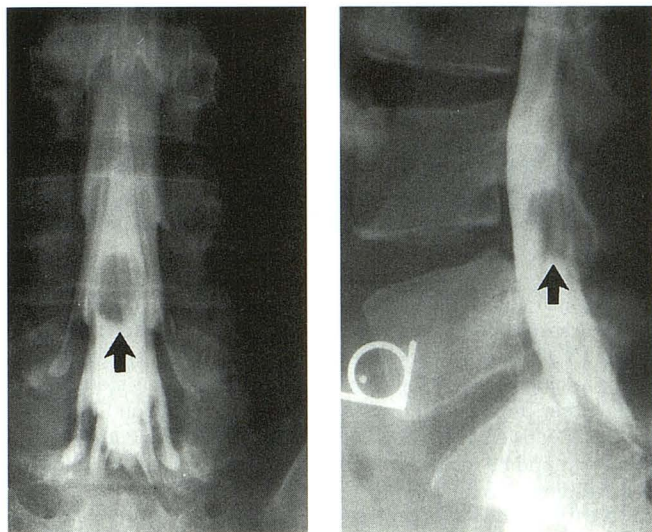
Anteroposterior and lateral radiographs from the myelogram demonstrating an intradural lesion at the L-4/L-5 level (black arrows).
